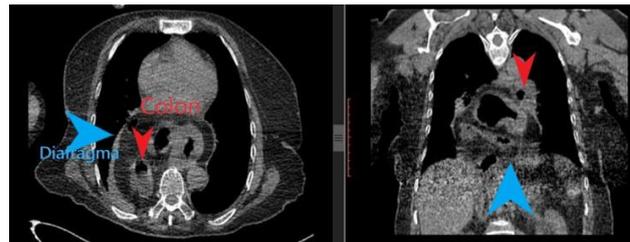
Axial and sagittal contrast-enhanced thoracic CT images showing a type 2 hiatal hernia
